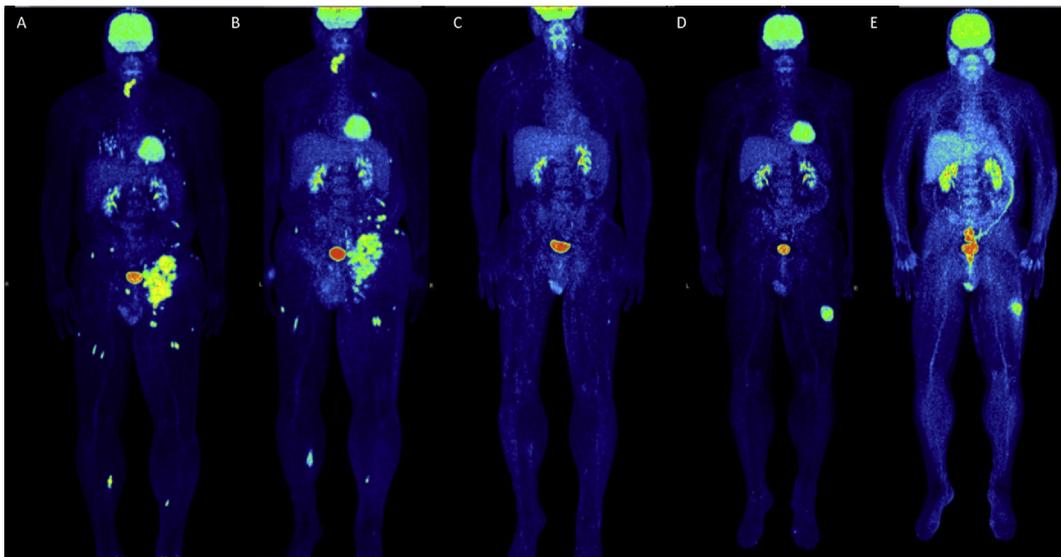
PET/CT scans before (A), after two cycles (B) and after four cycles (C) of initial ipilimumab treatment; the patient achieved a complete remission by ipilimumab, of note no signs of colitis. (D) PET/CT before retreatment with ipilimumab showing one progressing metastasis at the left vastus lateralis muscle which was radiated. (E) PET/CT after 12 weeks of ipilimumab reinitiation shows a stable disease and signs of colitis. PET, positron-emission tomography; CT, computed tomography.
